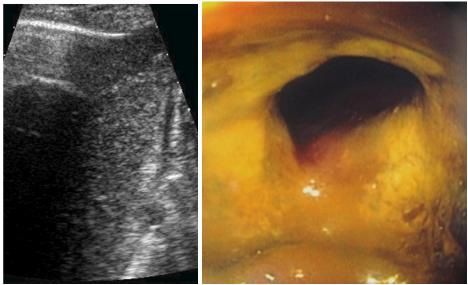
a, b Perforated bulb ulcer (in a, right gas-typical horizontal reflex) with some escaping liquid and gas (in a above) also between the liver and abdominal wall; UAS longitudinal; immediate surgery following (no CT!)
